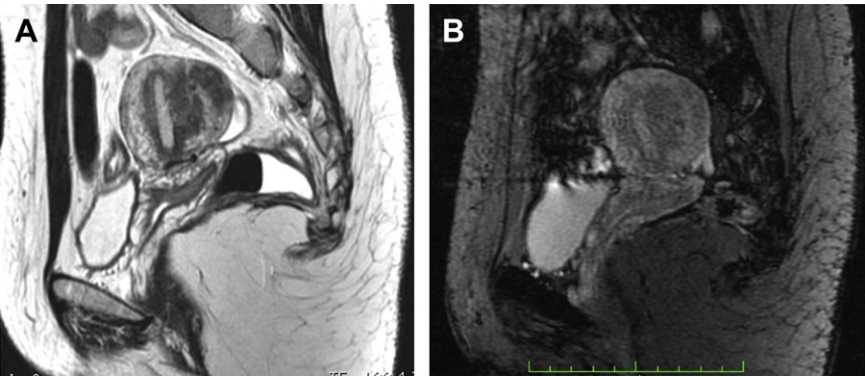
Adenomyosis. (A) Sagittal T2-weighted image shows posterior corporal thickened junctional zone with a hyperintense foci of heterotopic endometrial tissue. (B) Sagittal susceptibility-weighted MRI depicted discrete hypointense foci within the adenomyotic changes in the myometrium.
